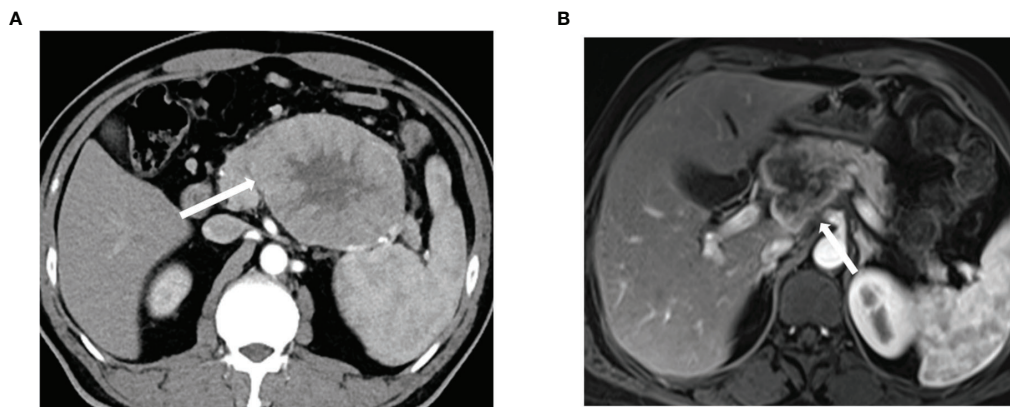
Biphase contrast enhanced computed tomography and magnetic resonance imaging of ACC (A) Venous enhancement is heterogeneous. (B) There is uneven enhancement of lesions in the portal arterial phase. ACC, acinar cell carcinoma.
